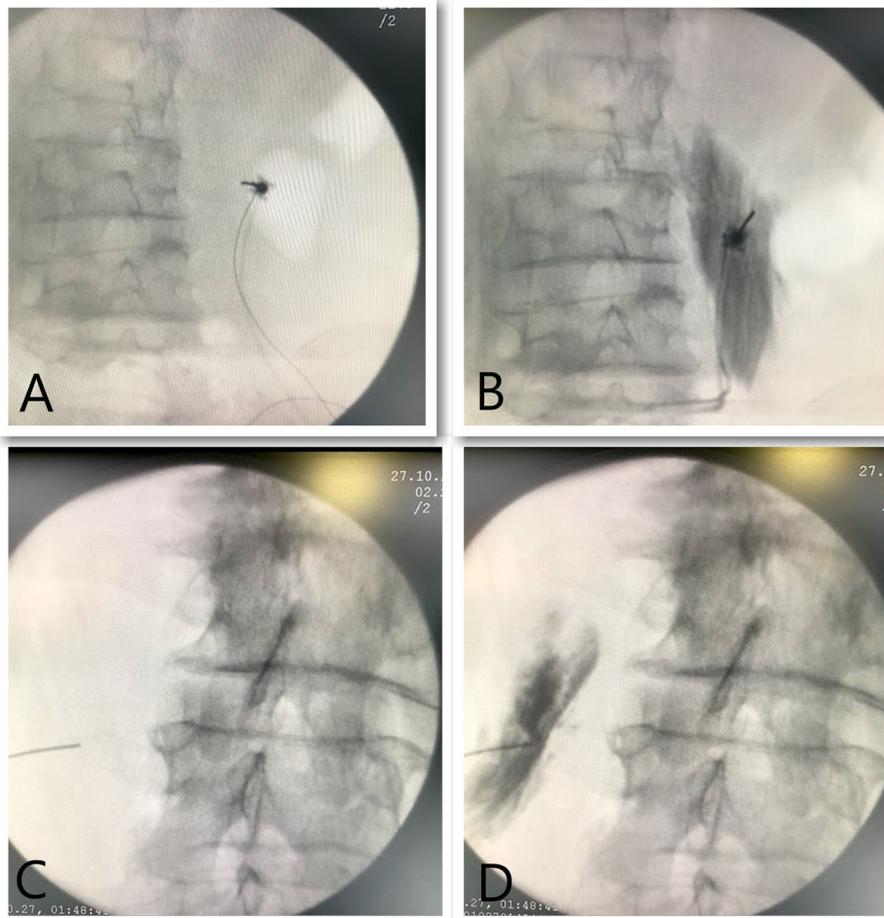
A X-ray showing contact of the needle in the middle of the transverse process. B Contrast spread close to paravertebral space. C Needle contacting the lower border of the transverse process. D Contrast spread along with the psoas muscle towards lumbar plexus. TP—transverse process
